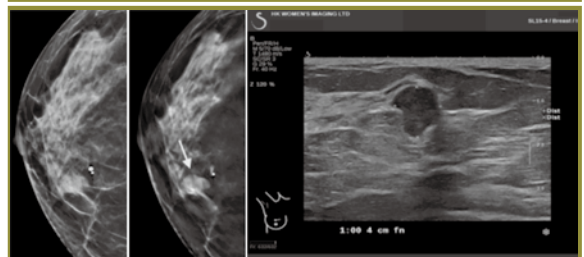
Tomosynthesis can identify lesions that can be missed in 2D mammogram. An oval mass is obscured in 2D mammogram (a). The mass is obvious in tomosynthesis (b). Ultrasound shows that it is a non-parallel lesion and subsequent biopsy confirms that it is an invasive ductal carcinoma (c).
